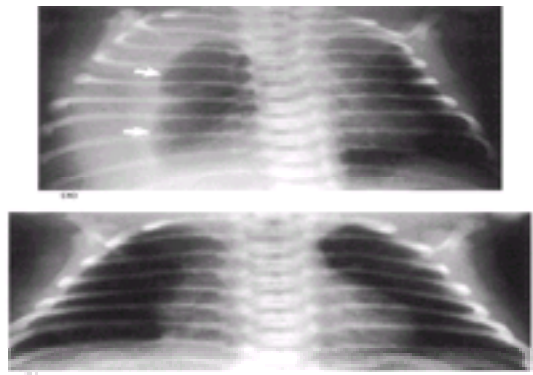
(a) Chest radiograph of a newborn infant with dyspnea and decreased breath sounds on the right side. Note collapsed right lung (arrows) caused by a chylothorax. Pleural drainage was instituted by a chest tube and the baby improved rapidly. (b) The tube was removed after 5 days as the drainage resolved. No further collection developed.
